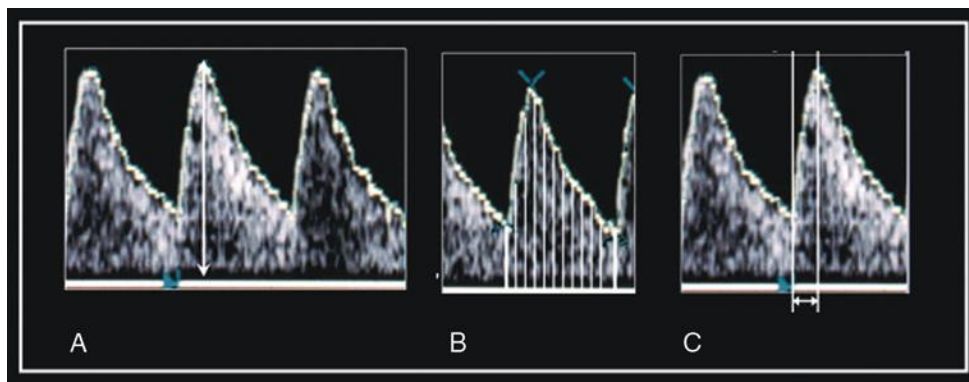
Doppler indices that are commonly used in fetal echocardiography: peak-systolic velocity (A), time-velocity integral (B), and time-to-peak velocity (C).
